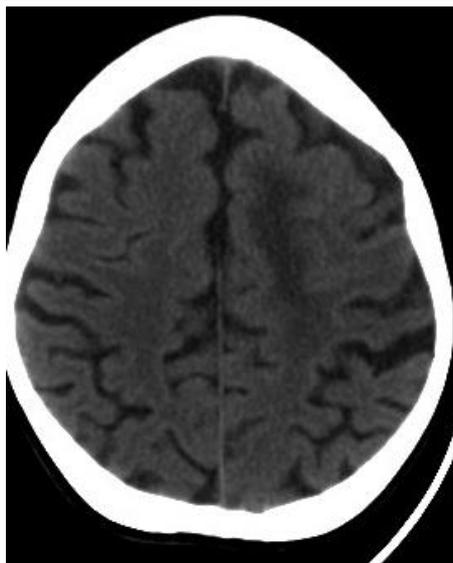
Non contrast Brain CT scan showing left frontal venous infarct
